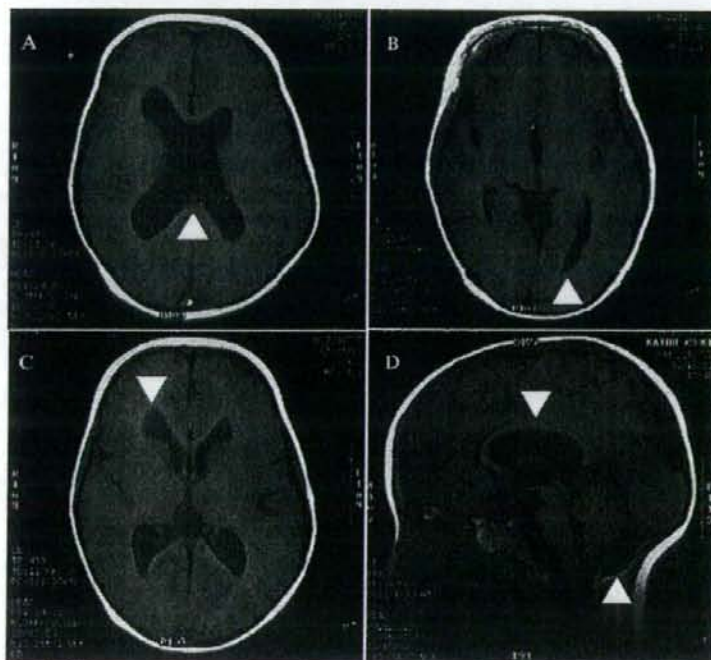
Magnetic resonance image (MRI) of the representative case (case 1). A to C, Axial sections of a T₁-weighted image; D, sagittal section of a T₁-weighted image. Arrowheads indicate abnormal lesions, which are typically observed in patients with Sotos syndrome (see Table 1).
